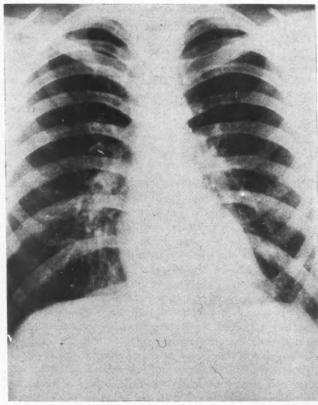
January 26, 1959. This radiograph was taken prior to discharge. There is a persistence of some linear and nodular opacities, congestive in appearance, in the right perihilar region and the middle third of the left lung. A small hazy density is noted in the region of the lung biopsy.
